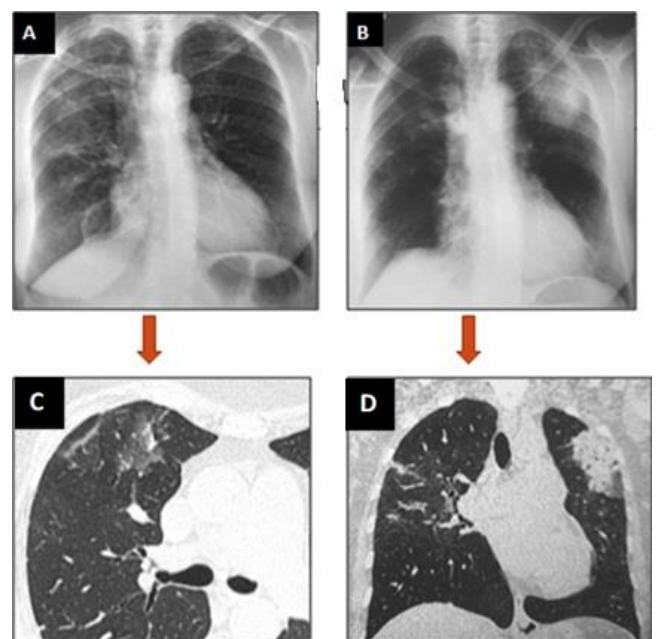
Patient's X-ray (A, B) and chest computed tomography scan (C, D) demonstrating ground-glass hyperdensity and migratory pulmonary condensations.
